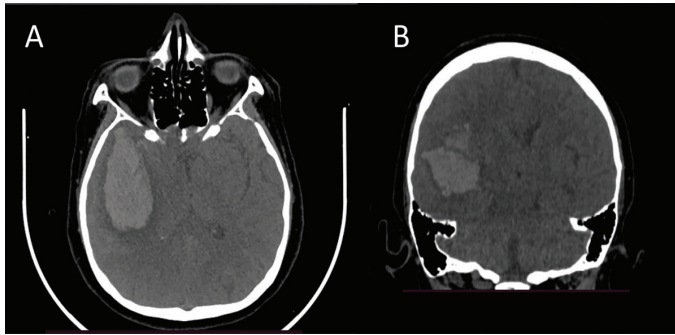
Preoperative cranial CT scan showing the acute parenchymal hemorrhage in the right temporal lobe with acute subarachnoid hemorrhage; (A) axial view at the level of the orbits, and (B) coronal view.
